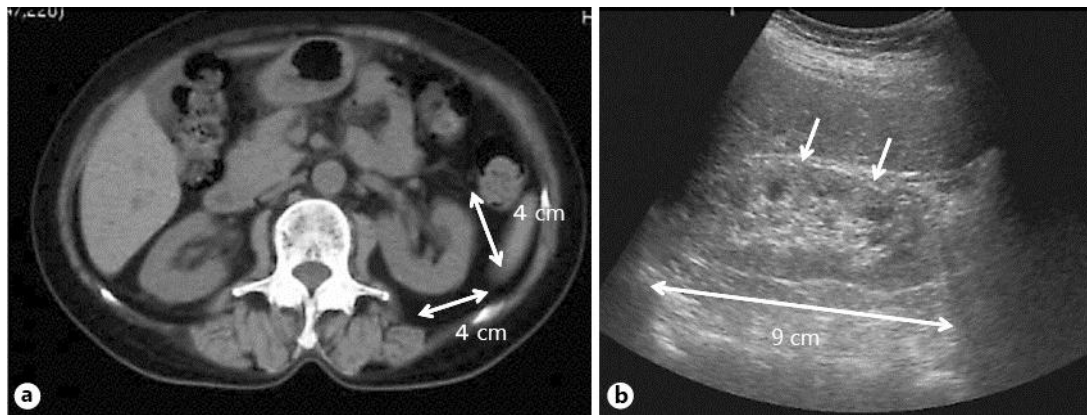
Imaging findings. a Computed tomography showed a decrease in kidney size with a long axis of 9 cm and a short axis of 4 × 4 cm bilaterally. b Ultrasonography demonstrated increased echogenicity (arrows) of the renal cortex.
